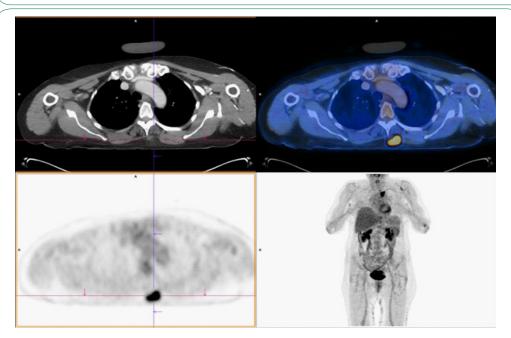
A hypodense lesion (4 cm) with intense FDG uptake (SUVmax 11.1) in the left paravertebral musculature.
